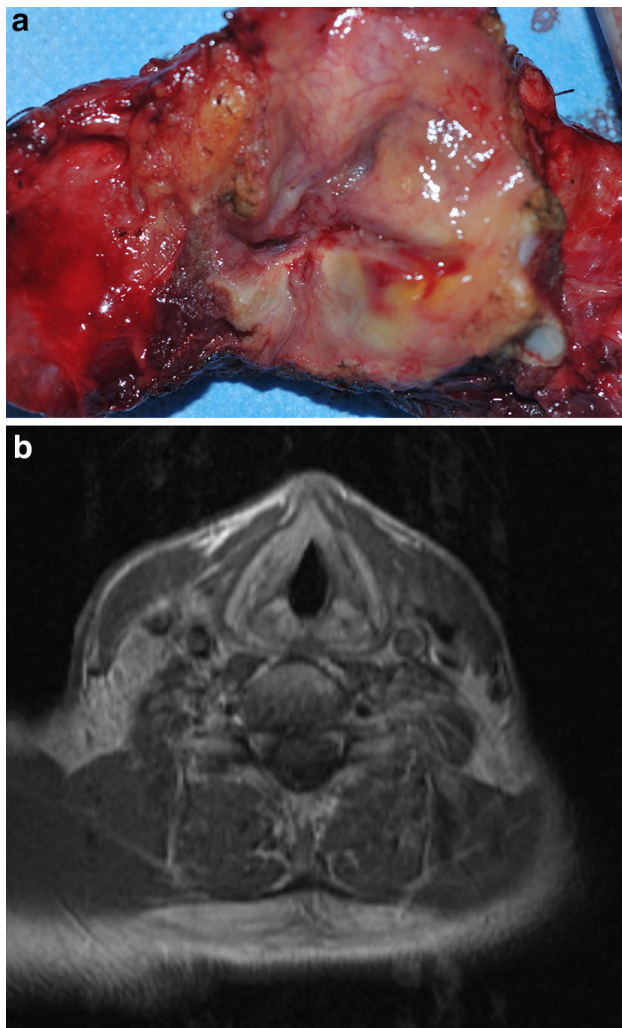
a Tumor invading both supraglottis and glottis, which demonstrated thyroid cartilage invasion in the final pathology report. b T1-weighted contrasted MRI image of the same patient showing any invasion of the thyroid cartilage
